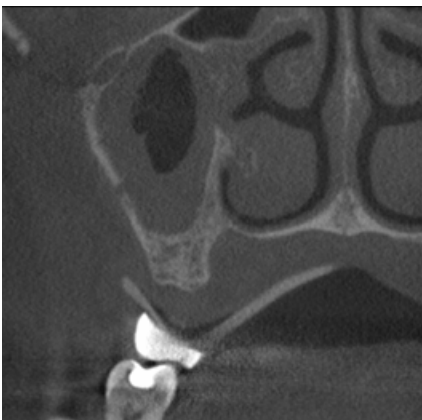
Coronal CBCT image, second molar region
